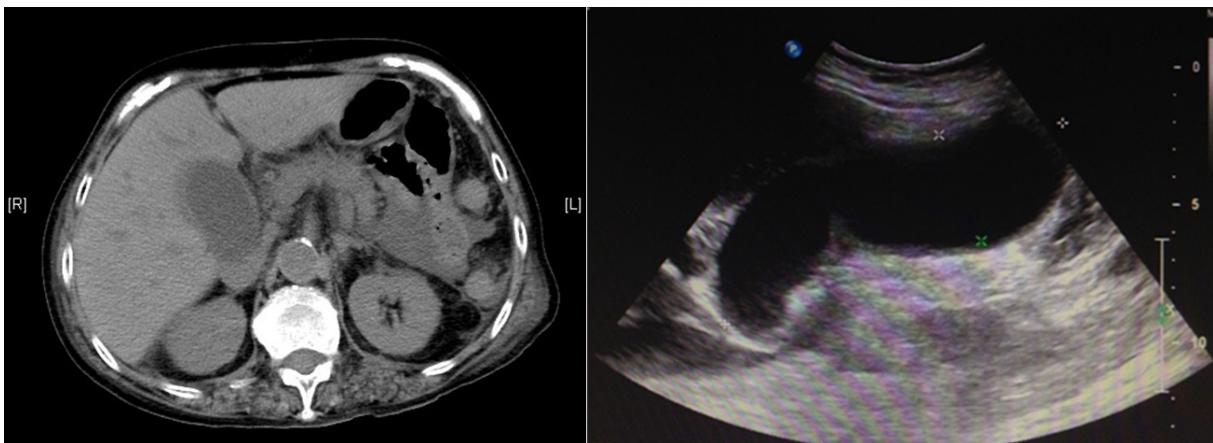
Abdominal CT scan and ultrasound showing cholecystitis.
